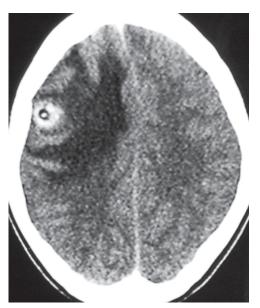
CT image showing a solitary cysticercus granuloma with perifocal edema
